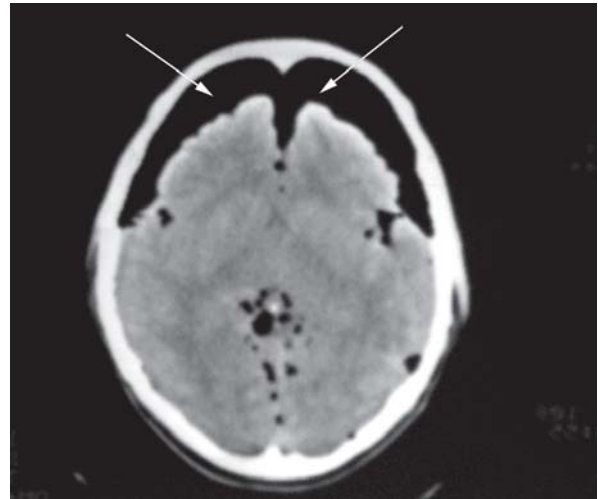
CT scan head showing massive pneumocranium of anterior cranial fossa
